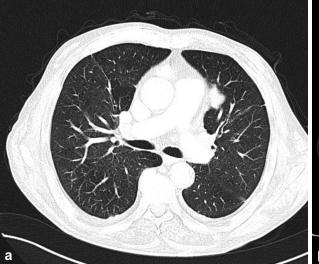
(a and b) Myxofibrosarcoma: CT aspect of the mediastinal pleural metastasis, measuring 3×2 cm.
